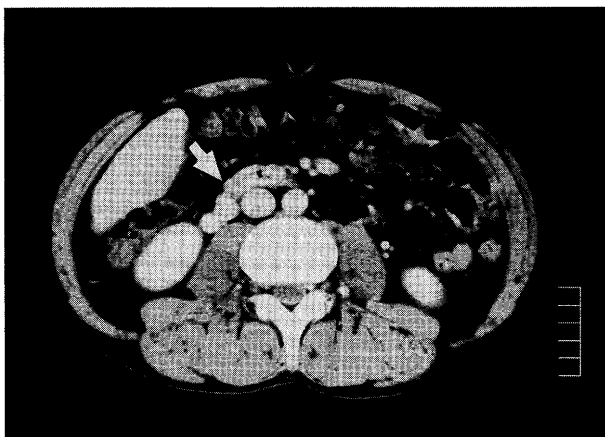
Contrast-enhanced CT showed markedly tortuous vessels around the third portion of duodenal wall and enlarged gonadal vein, slight liver cirrhosis, but no ascites nor splenomegaly.
